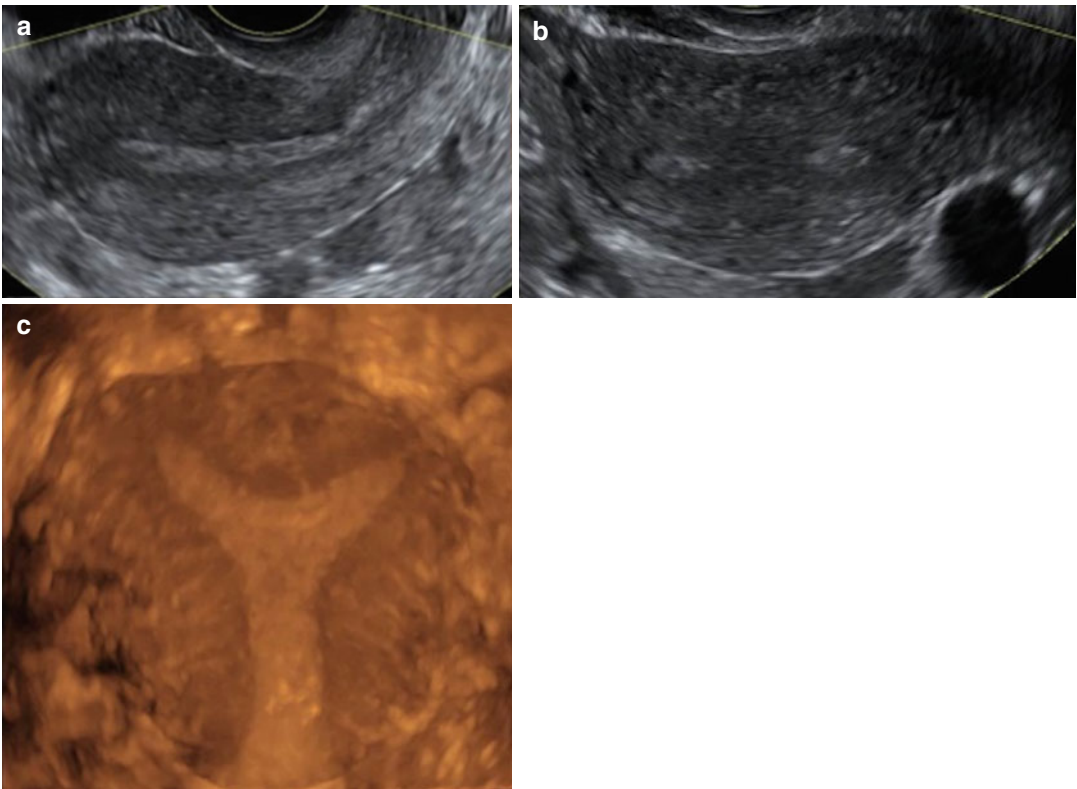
Transverse 2D ultrasound does not allow for accurate assessment of the fundal myometrium. (a) Sagittal 2D image. (b) Transverse 2D image: an interrupted endometrial line is visible despite the poor contrast
